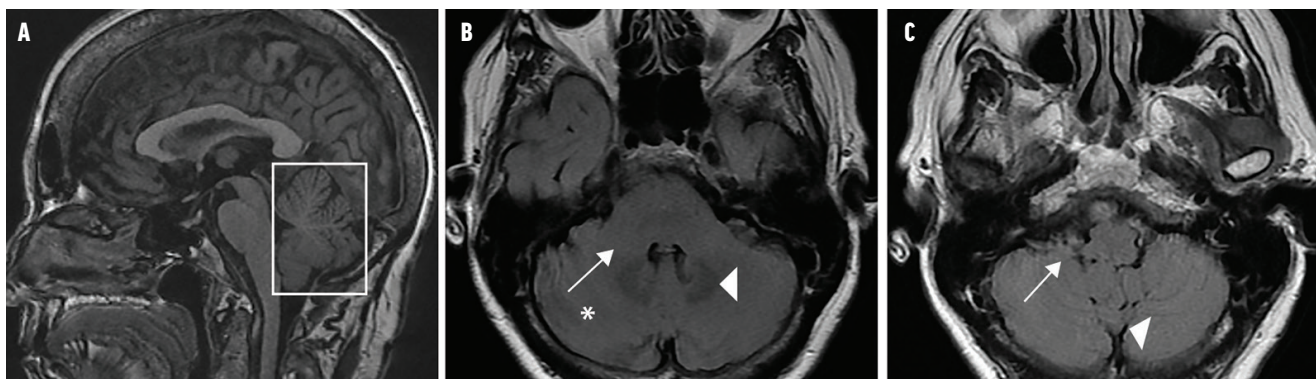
Cerebellar regions commonly visualized on brain MRI include the vermis (A, box) on a T1 midsagittal section and the dentate nucleus (B, arrowhead), middle cerebellar peduncle (B, arrow), lateral hemisphere (B, *), flocculus (C, arrow), and nodulus (C, arrowhead) on axial fluid-attenuated inversion recovery (FLAIR) sequences. Lesions of the vermis cause head, trunk, and stance ataxia. Lesions in the lateral hemispheres and cerebellar nuclei cause limb or appendicular ataxia, dysarthria, and cerebellar cognitive affective syndrome (CCAS). Flocculonodular lobe lesions cause oculomotor and vestibular signs (eg, nystagmus and Romberg sign).
